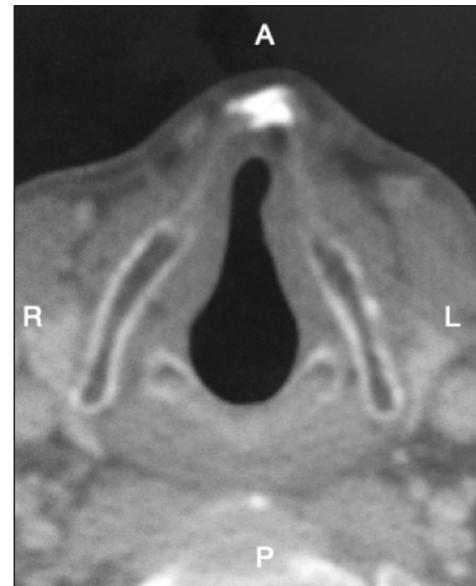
Laryngeal CT scan with contrast, axial view, showing a soft tissue prominence of the left glottic cord relative to the right.
